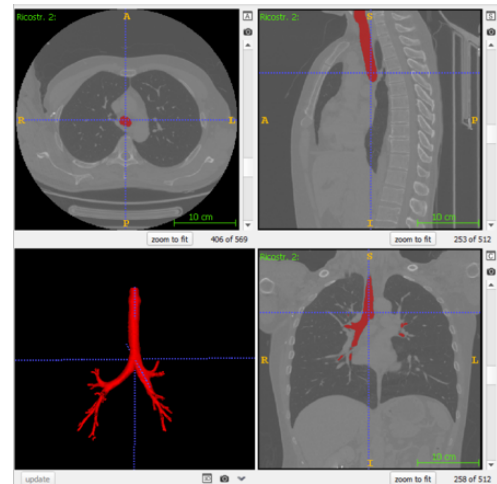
Digital model of the tracheobronchial tree obtained through the CT segmentation process.
